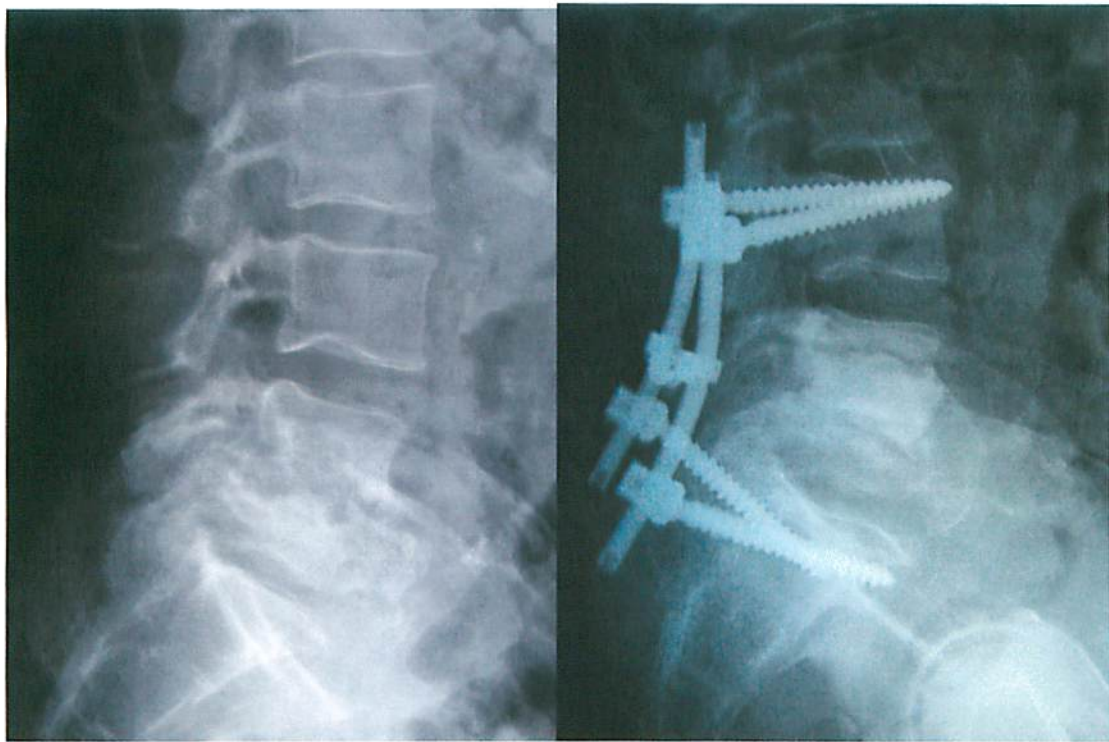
Pre and Post operative X-rays which confirm fusion. The AI-PMMA can be seen in L4-L5 disc space.
